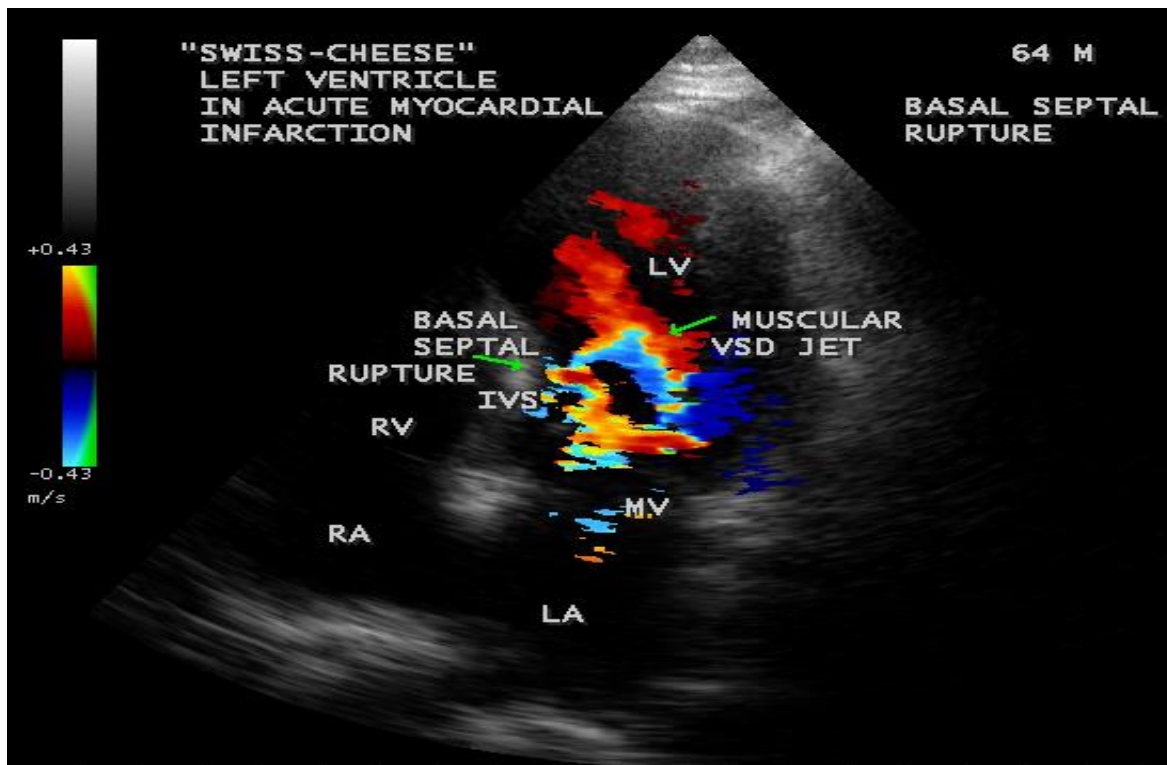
Apical four chamber view showing the basal septal rupture
